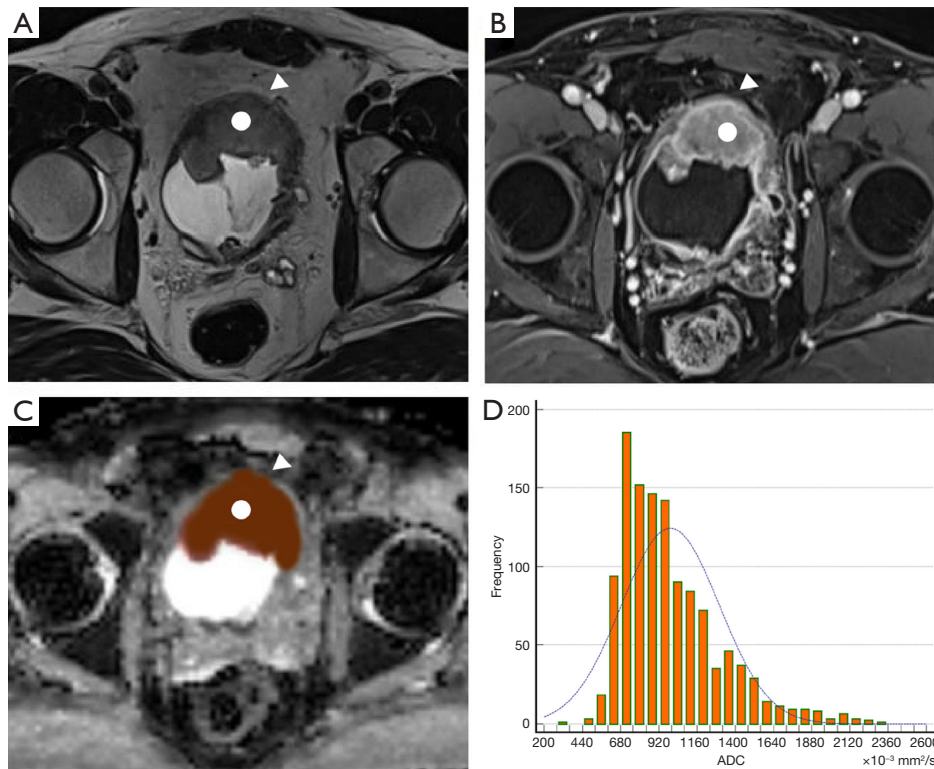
A 55-year-old man with T3 stage papillary urothelial carcinoma in the anterior bladder wall. The lesion (white circle) had an intermediate signal on T2WI (A), was obviously enhanced in the DCE image (B) and had a low signal in the ADC map (C). The line signal of the bladder wall adjacent to the lesion was interrupted and perivesical fat was slightly invaded (white triangle). The ADC histogram of the corresponding lesion is shown in (D). T2WI, T2-weighted imaging; DCE, dynamic contrast-enhanced; ADC, apparent diffusion coefficient.
